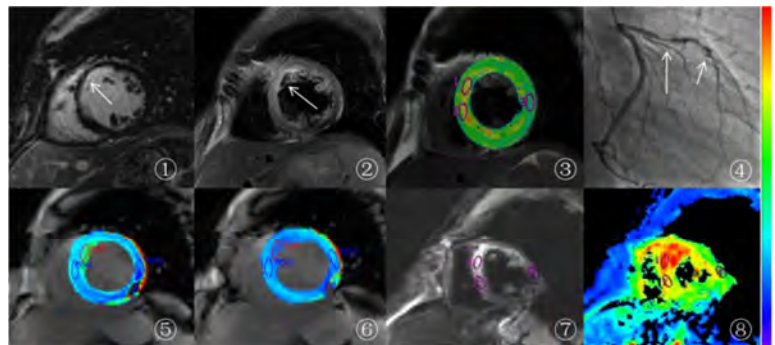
A recent MI patient with approximately 70% transmural anteroapical myocardial infarction. A strip of high signal at the infarction region could be seen in LGE images, ①, and T2WI images ②. From the quantitative T2 mapping, ③, values of the infarction region, 103.3ms, much higher than the remote region, 59.4ms, which indicated myocardial edema happened. From the coronary angiography, ④, moderate to severe stenosis of the proximal and middle left anterior descending artery that supplies the anteroapical wall observed. The measurements of pre-, ⑤, and post-contrast, ⑥, T1 mapping permit CRT and ECV computation. The signal intensity at DWI, ⑦, and the ADC value of the infarction zone, ⑧, are both higher than the normal regions.
